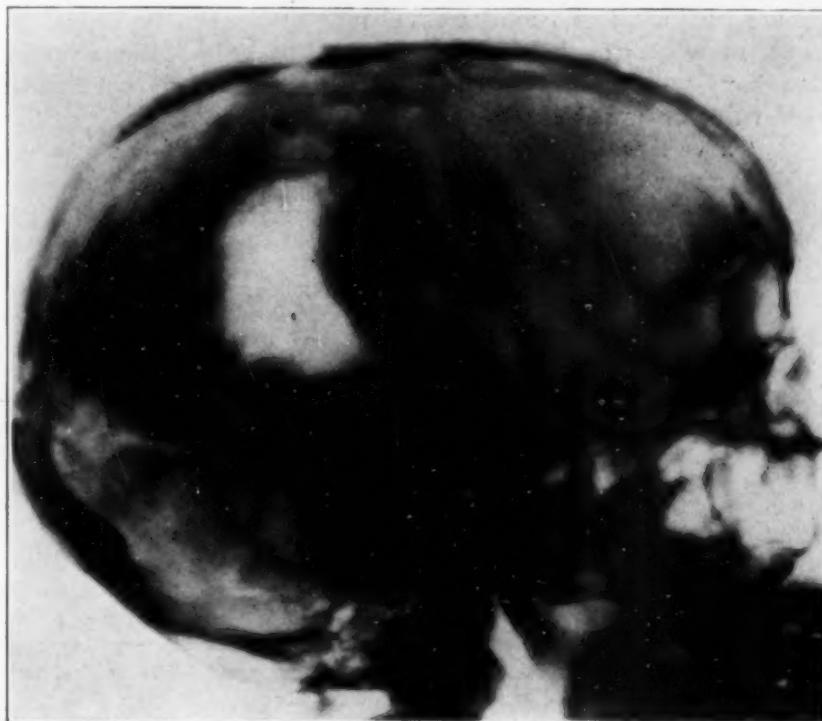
Cystic subcortical glioma in the right parietal lobe. Roentgenogram showing air in the cyst cavity and enlarged anterior temporal veins on the same side.
